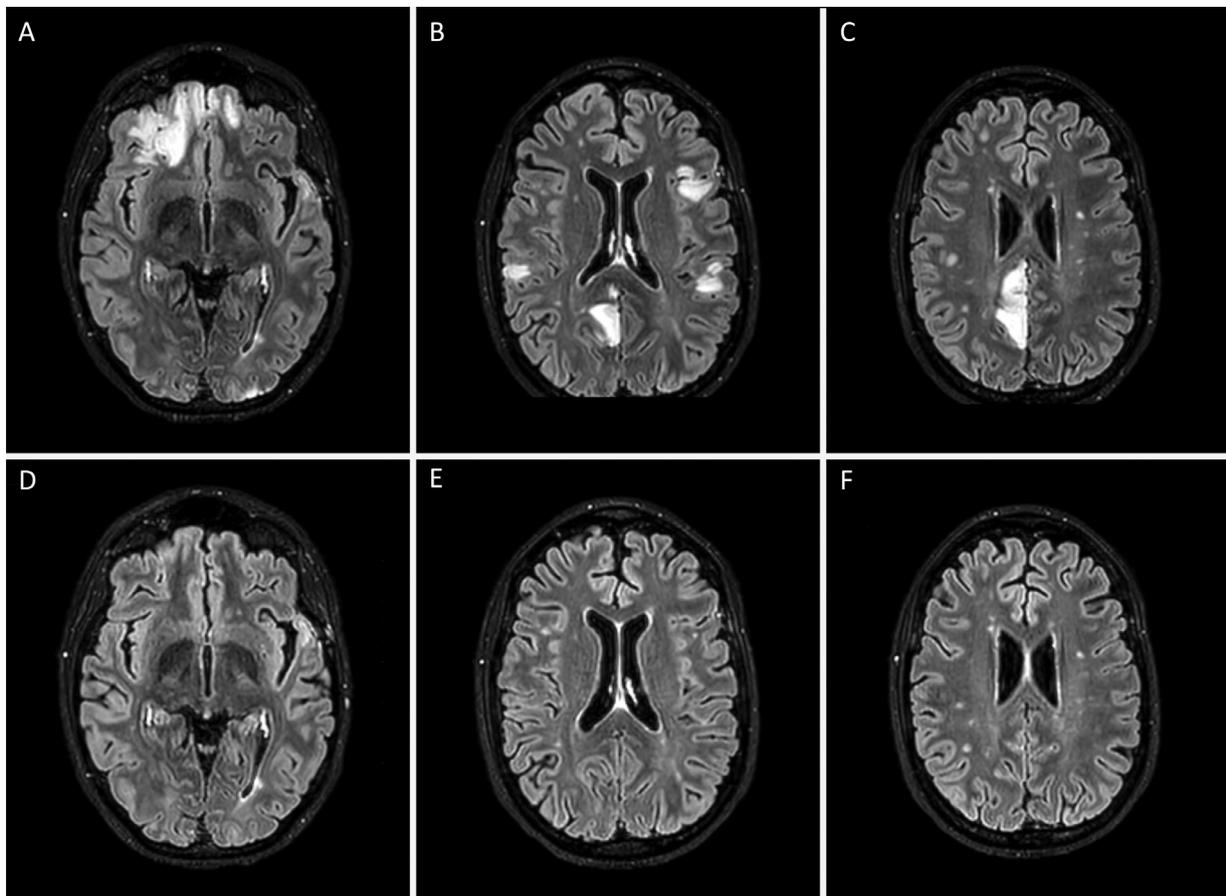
Disease course of AE. (A – C) MRI from 24 September 2018 demonstrates large areas of T2/FLAIR hyperintensity involving the cortical and subcortical white matter of both frontal, parietal and occipital lobes. (D – F) Progress imaging following treatment with ocrelizumab showing complete resolution of these changes. Resolution of MRI change correlated with induction of a sustained clinical remission.
